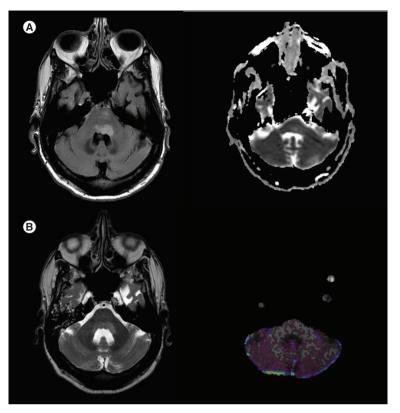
Axial images from MRI with top left: FLAIR, top right: apparent diffusion coefficient (ADC); bottom left: T2; bottom right: cerebral blood volume. (A) MRI 7 months after diagnosis of systemic lymphoma demonstrating a FLAIR hyperintense lesion in the dorsal pons without enhancement or reduced diffusion. (B) Imaging of local relapse several months later demonstrating a T2 hyperintense, nonenhancing dorsal pontine lesion with normal cerebral blood volume.
